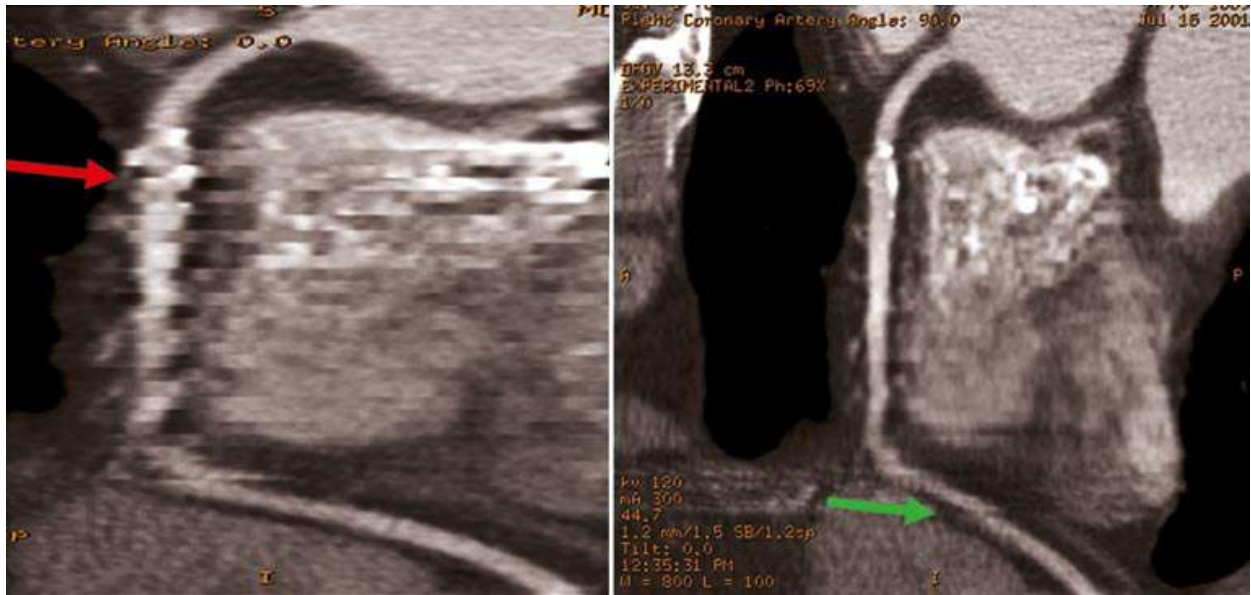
Light Speed-16 CT angiography images.
